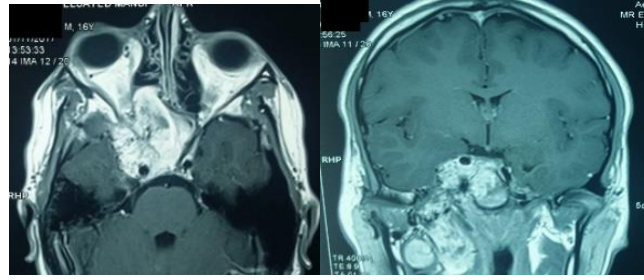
MRI images of a case with JNA in right side of the nasal cavity, PPF, ITF, nasopharynx and bilateral side of sphenoid sinus with intracranial extension encasing the right ICA and invading right cavernous sinus. (Stage IV B)
